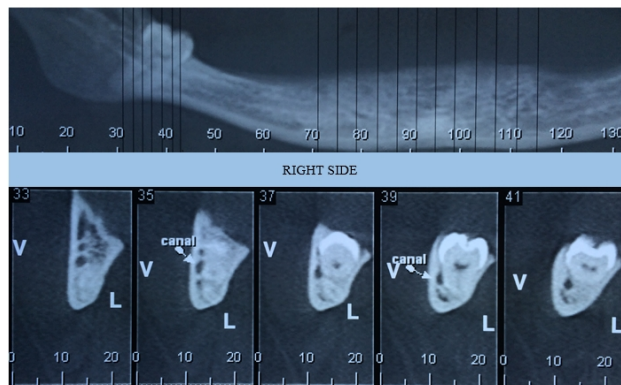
Pre-extraction cone beam TC: observe intimate relationship between the tooth and the alveolar canal, and reduced bone volume around the third molar. Canal: alveolar canal.
